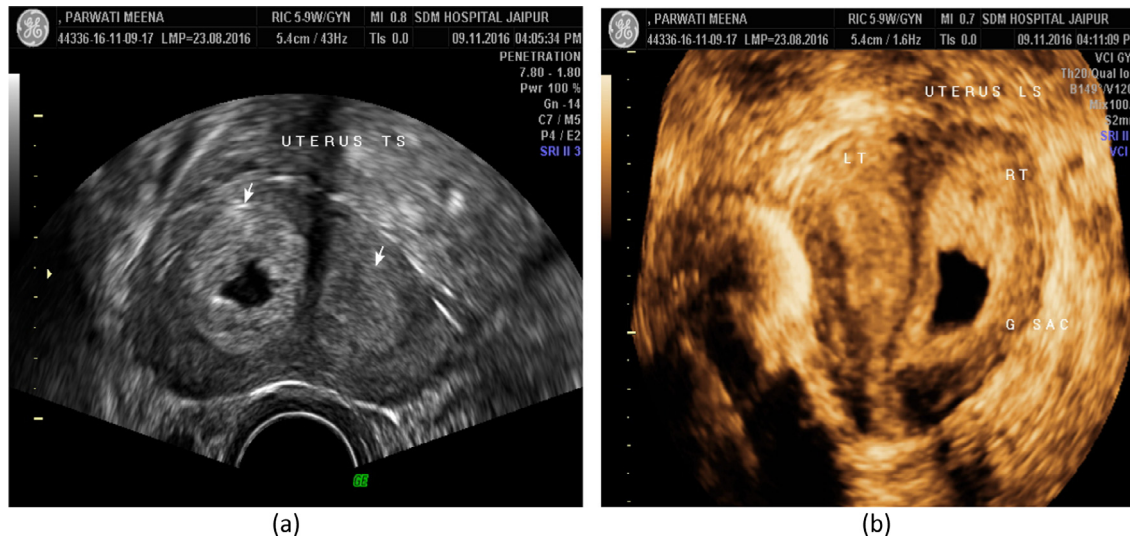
(a and b) Two dimensional and three dimensional ultrasonography showing bifurcated endometrial canals. There is gestational sac in the right moiety. There is no myometrial dip in the fundal region.
